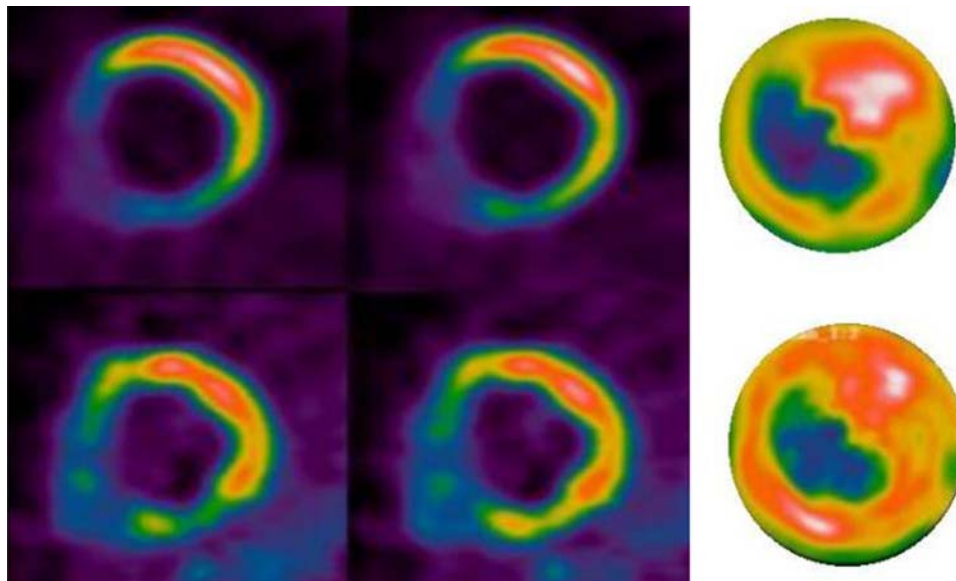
Two short-axis slices and one polar map, bull’s-eye display of a PET FDG, above, and a PET Rb-82, below. There is a moderate to large sized, severe defect in the anterior- and inferior-septal regions that shows the same (MATCHING) severity on FDG and Rb-82 to indicate that the myocardium is no longer viable, implying a nearly transmural extent of scar tissue, as suggested by Figure 1B.
